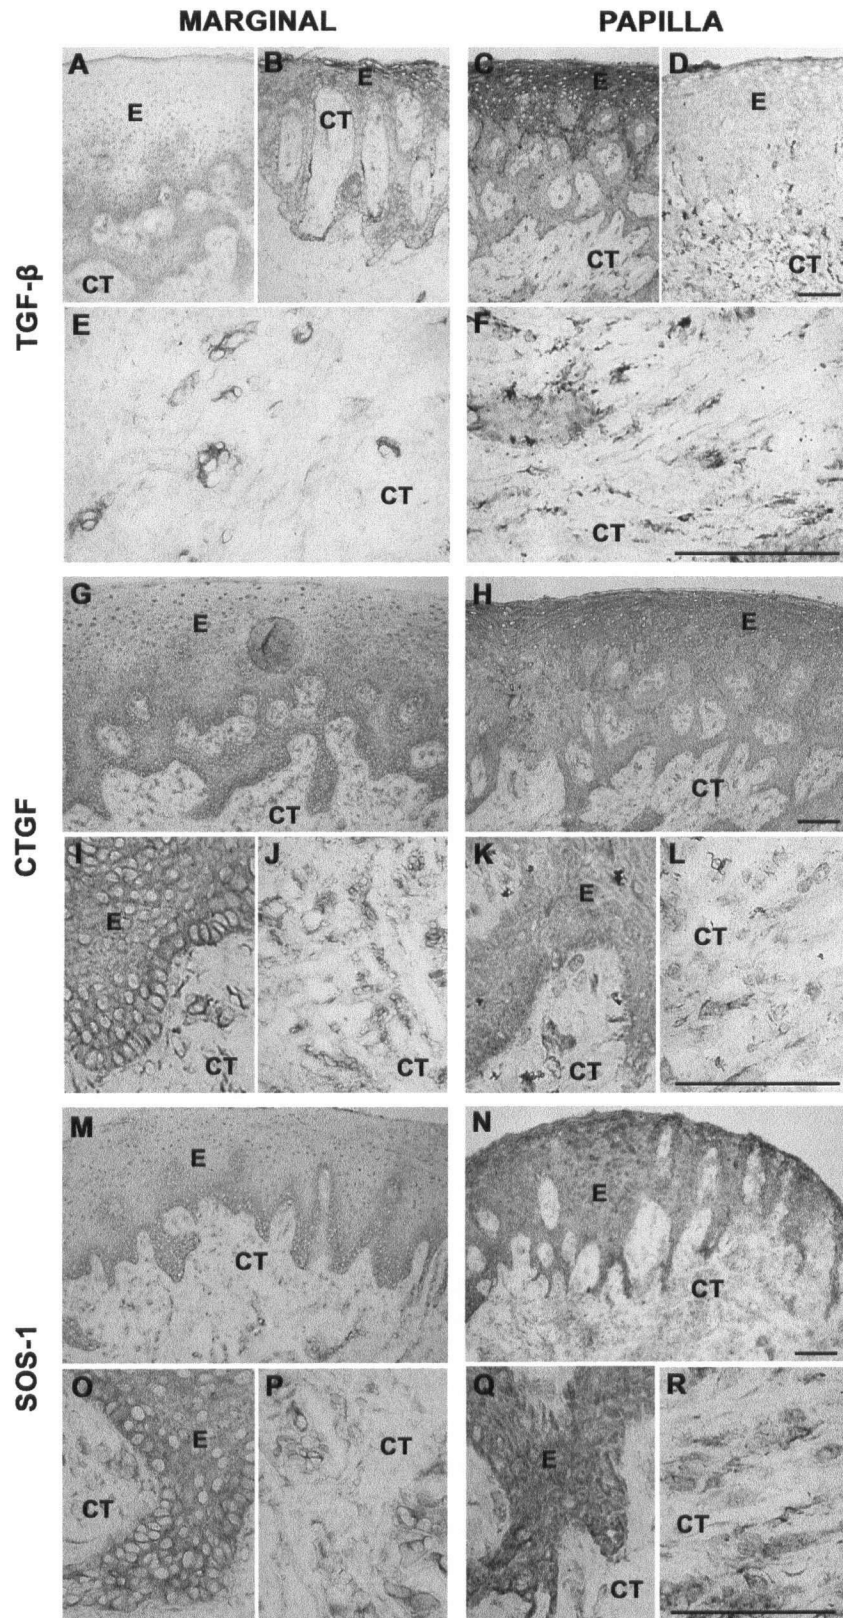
Localization of TGF- β (A-F), connective tissue growth factor (CTGF; G-L) and SOS-1 (M-R) in healthy marginal gingiva (A, B, E, G, I, J, M, O and P) and interdental papilla (C, D, F, H, K, L, N, Q and R). E=epithelium; CT=connective tissue. Bar 100 μ m
